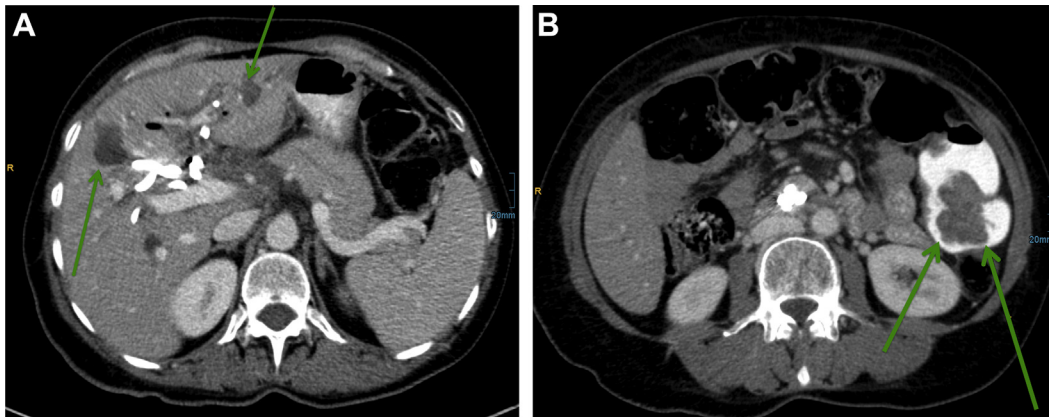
CT axial image of liver metastasis with signs of cystic degeneration (A, green arrows). Intraluminal mass of distal sigmoid colon (B, green arrows).
